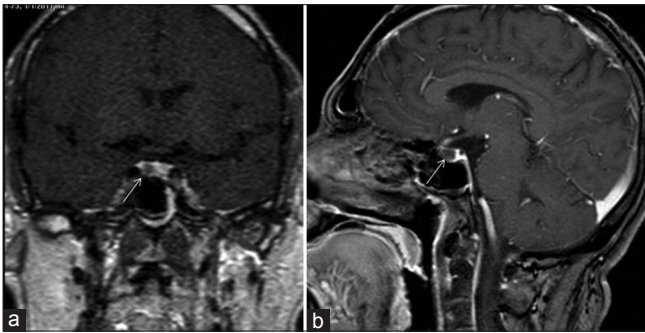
Pituitary microadenoma. A 30-year-old male with features of Cushing's syndrome due to pituitary microadenoma. High-resolution dynamic contrast-enhanced T1-weighted coronal (a) and sagittal (b) images of brain (at 60 s) show a small nonenhancing (dark) microadenoma (arrow) lateralized to right side of the pituitary gland. The normal pituitary gland shows marked homogenous enhancement
